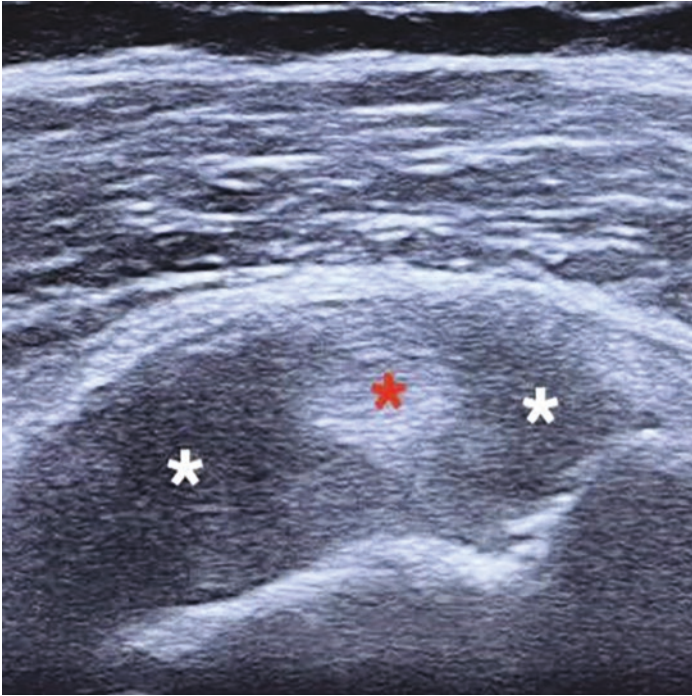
Short-axis ultrasound image showing a large effusion (white *) around a biceps tendon (red *)
